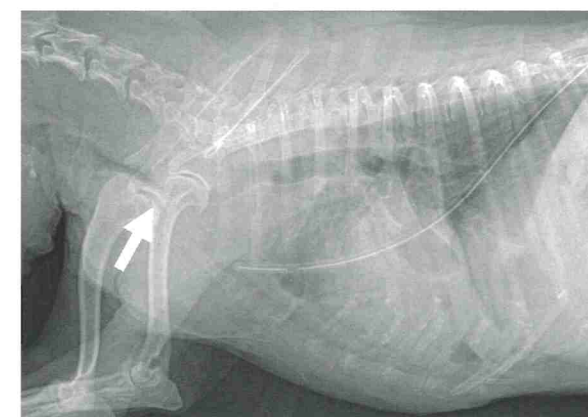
Lateral thoracic radiograph after the operation. Note that the trachea severely collapsed from the cervical to pectoral region (white arrow).
